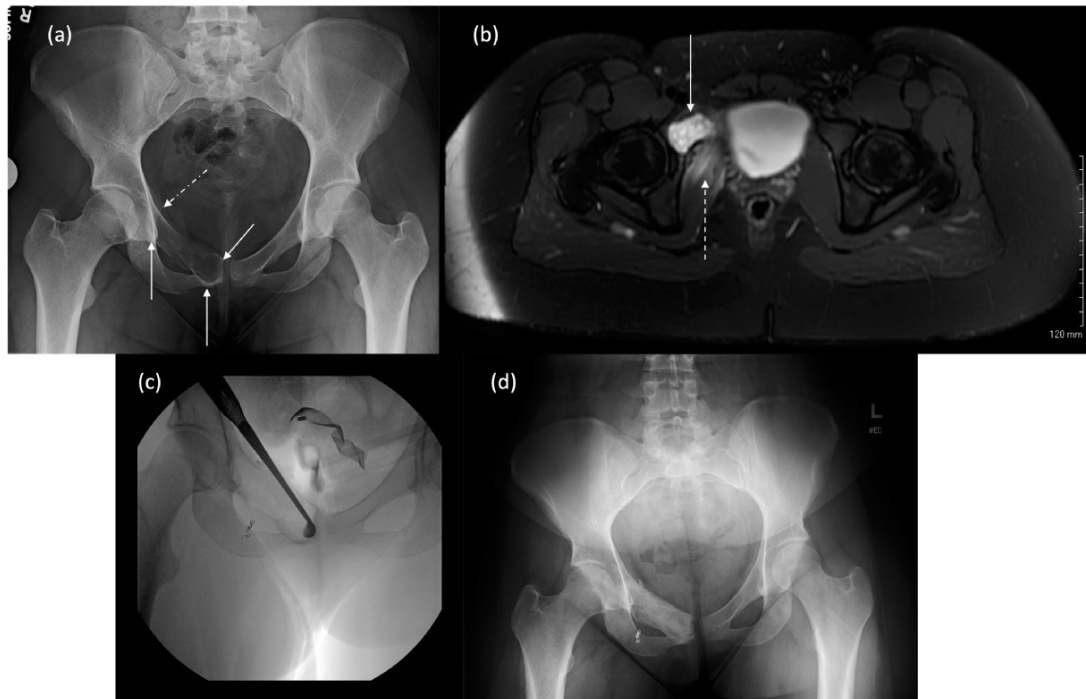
Preoperative and postoperative imaging of Patient 2's right hip. (a) Preoperative standing AP pelvic radiograph demonstrating an expansile, predominantly lytic lesion in the right superior pubic ramus (solid arrows) with an associated pathologic fracture (dashed arrow). (b) Preoperative axial T2-weighted MR image demonstrating a corresponding multisepated T2 hyperintense lesion (solid arrow) with reactive edema of the adjacent obturator internus and pectineus muscles (dashed arrow) potentially related to either a strain or an occult pathologic fracture. (c) Intraoperative AP fluoroscopic image showing resection of the lesion prior to packing with bone graft. (d) Postoperative AP pelvis radiograph at the 6-month interval showing central bone graft without evidence of recurrence or resorption and preserved joint spaces.
